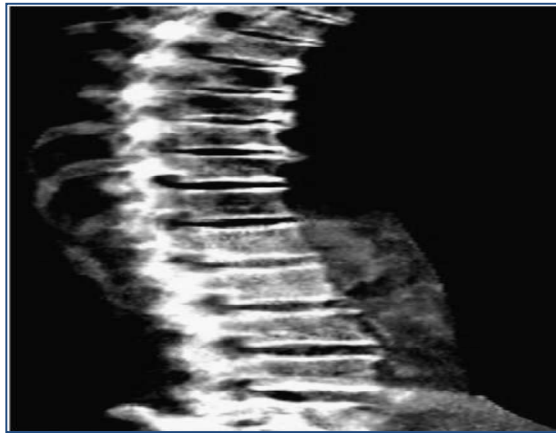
Example of vertebral fracture assessment using dual X-ray absorptiometry in a patient with ankylosing spondylitis (El Maghraoui, 2011).
